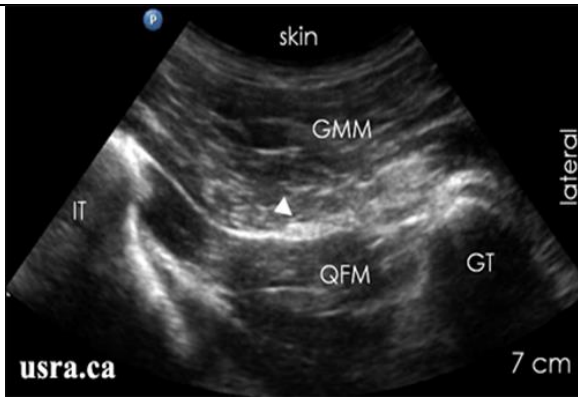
Ultrasound image shows the sciatic nerve (arrowhead) relative to surrounding structures (adapted from Ultrasound for Regional Anesthesia).
